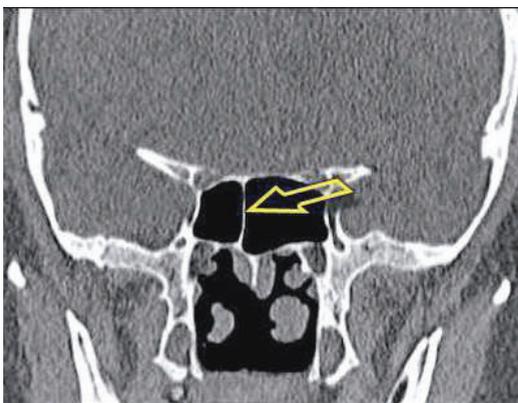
CT scan of the paranasal sinuses, frontal plane. Total number of septa — 1, total number of antra in the sphenoid sinuses — 2 (1/2).
